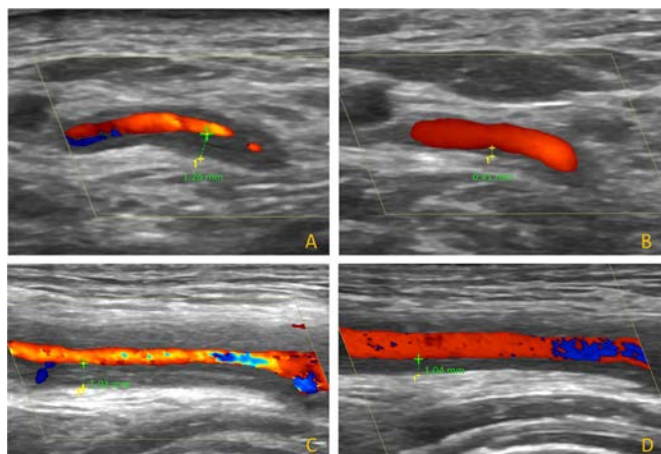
Ultrasound halo sign of the temporal and axillary arteries at baseline and week 24. Patient one (A and B); patient two (C and D). Both patients were in clinical and laboratory remission at week 24; however, patient two still presented an AX halo sign but with a lower IMT in comparison to baseline. (A) Left common superficial temporal artery at baseline showing a halo sign (maximum IMT of 1.28 mm). (B) Left common superficial temporal artery at week 24 with no halo sign (maximum IMT of 0.41 mm). (C) Left axillary artery at baseline showing a halo sign (maximum IMT of 1.91 mm). (D) Left axillary artery at week 24 still showing a halo sign (maximum IMT of 1.04 mm). IMT, intima-media thickness.
